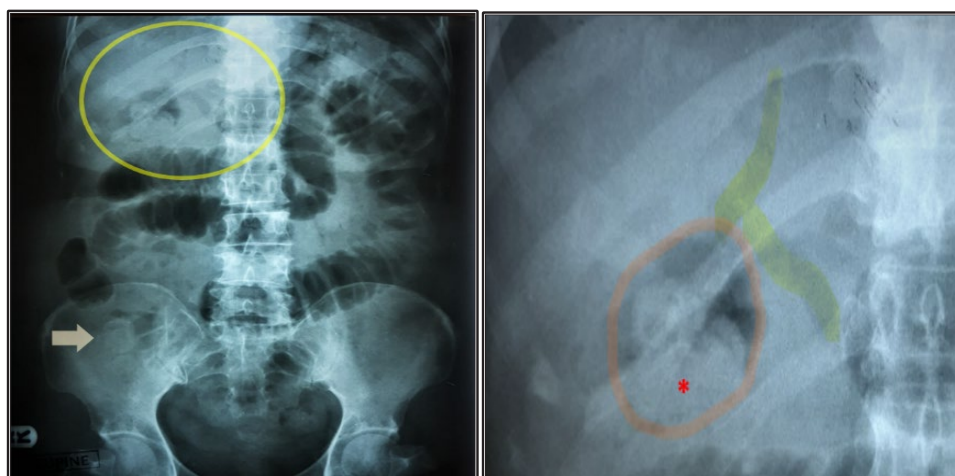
Rigler’s triad in abdominal X-ray- aerobilia (yellow highlight), aberrant gallstone (arrow) and small bowel obstruction. Gallbladder with radiopaque stones (red highlight and asterisk)
